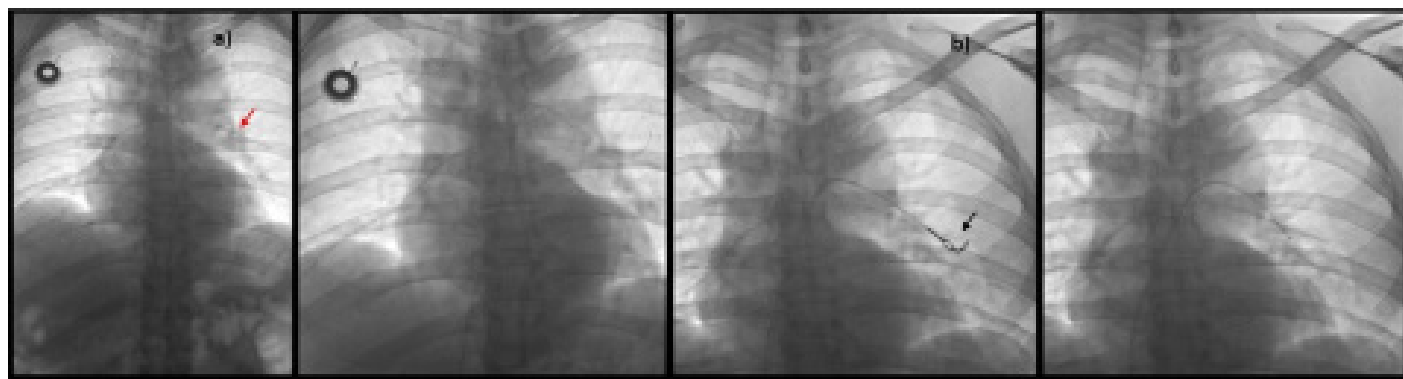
Endovascular retrieval of a dislodged port catheter using the gooseneck loop snare technique. a) A plain radiograph demonstrates the embolized catheter fragment extending from the right ventricle to the left main pulmonary artery (red arrow). b) The displaced proximal tip is caught with a gooseneck loop snare (black arrow) introduced via femoral venous access, enabling successful retrieval of the fragment.
